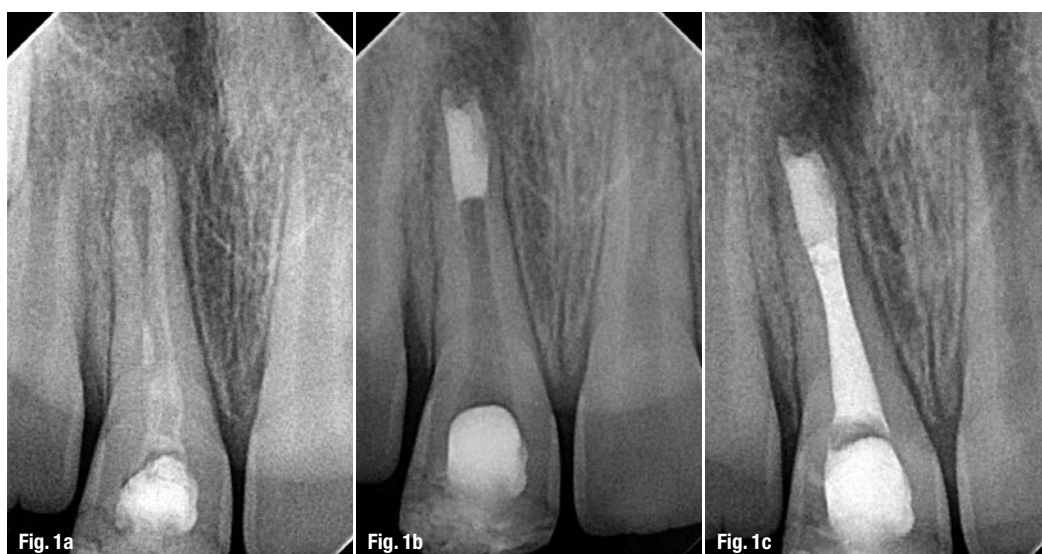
Pre-op radiograph of tooth #11 with Ca(OH)₂ dressing from the referring doctor.
